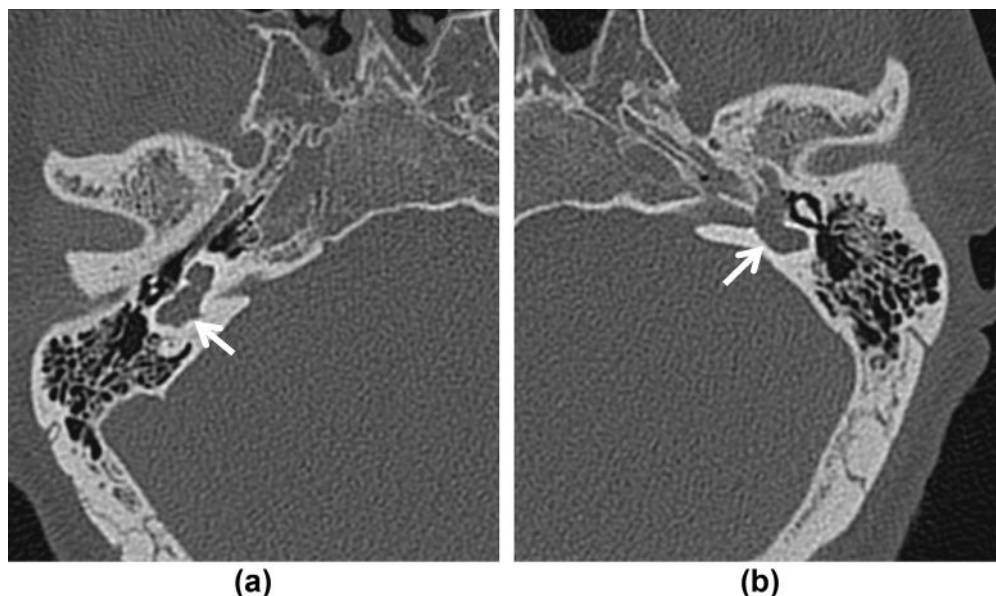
A 48-year-old man with anomalies of the bilateral auditory organs resulting in bilateral hearing impairment. High-resolution CT images of the temporal bone in the axial plane showed hypoplasia of bilateral semicircular canals, cochlea, vestibule, and right malleus. Lateral semicircular canal, cochlea, and vestibule formed cavities (arrows) on both sides.
